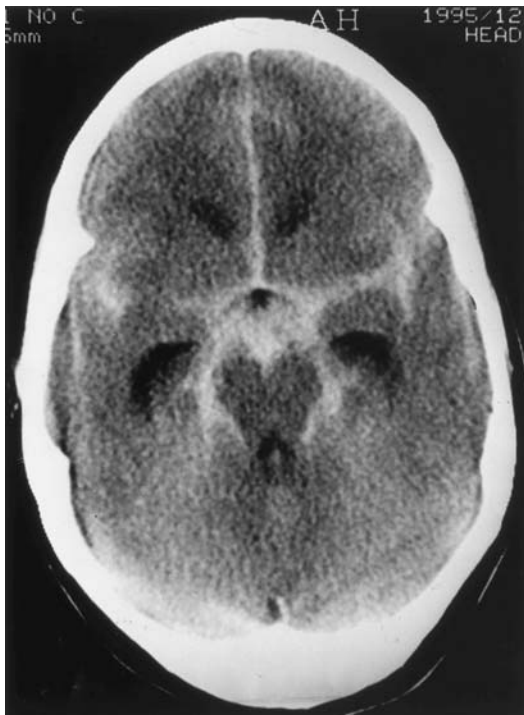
CT scan demonstrating an aneurysmal subarachnoid hemorrhage.
